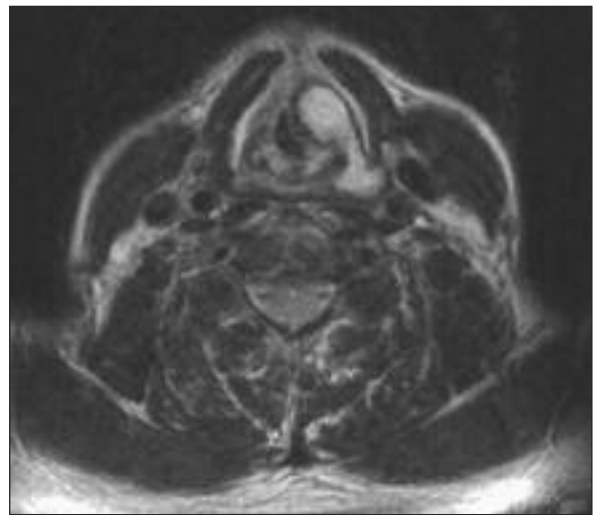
The lesion is also hyperintense on the axial T2 weighted MR image.
